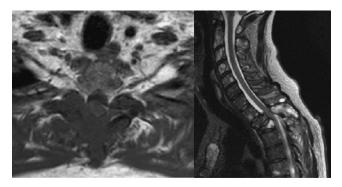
MRI with axial image of lesion and sagittal cut demonstrating vertebral body collapse at T2 and T3, anterolisthesis of T1 on T2, infiltration of the posterior elements, and cord compression.
